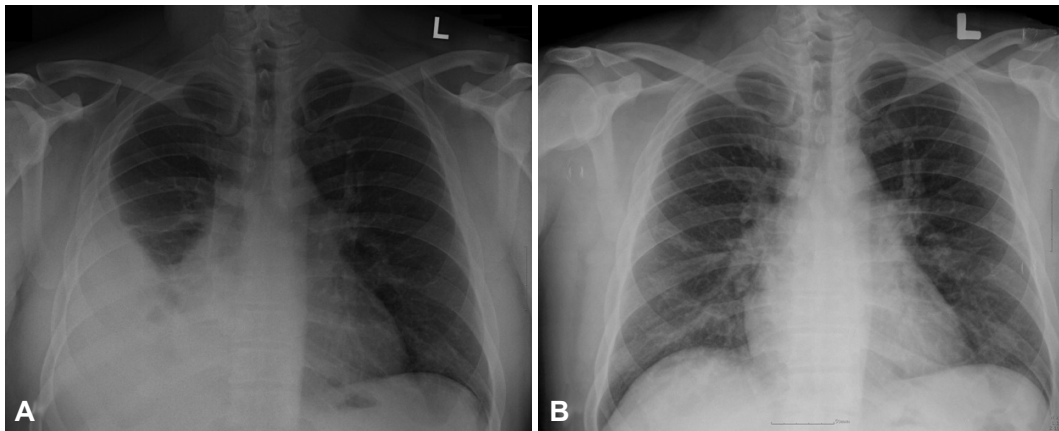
Chest X-ray demonstrated a large right pleural effusion on current admission (A) and scanty pleural effusion before the warfarin administration (B).
